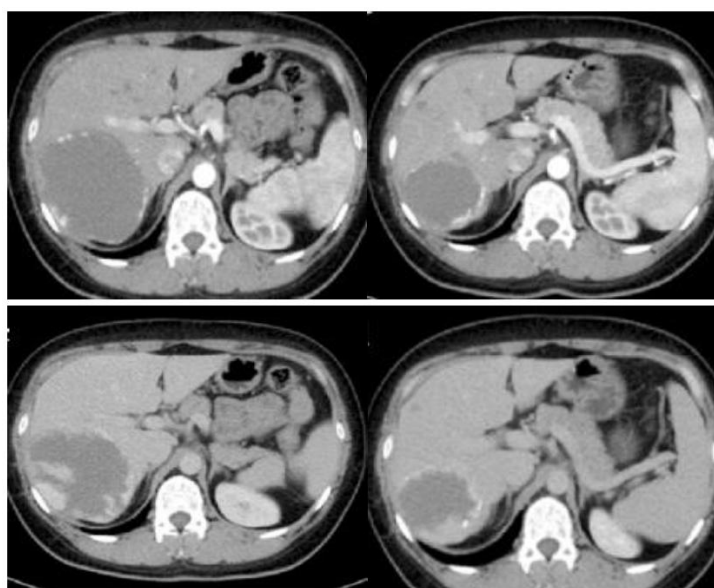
38 years old female. CT triphasic protocols, pictures during follow up of 4 months pre-embolization CT scan measured (10x 8.5x4.5cm) (left) and (post embolization follow up at 4 months measured (8.7x 6.5x3.2cm) (right)
